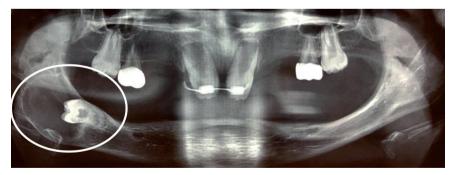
Panoramic x-ray of the patient in 2018: White circle showing the cystic formation around the impacted tooth.
